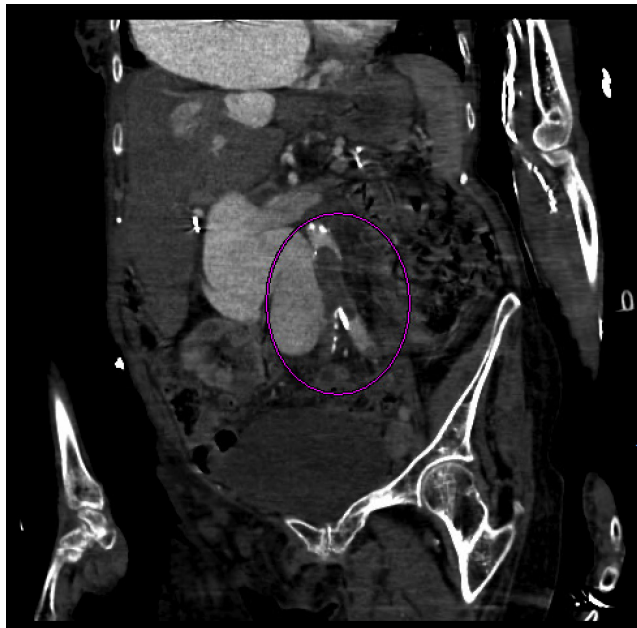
CT-angiography of abdominal aorta, coronal view. There is a thrombus in distal aorta, extending to iliac arteries bilaterally (circle).
